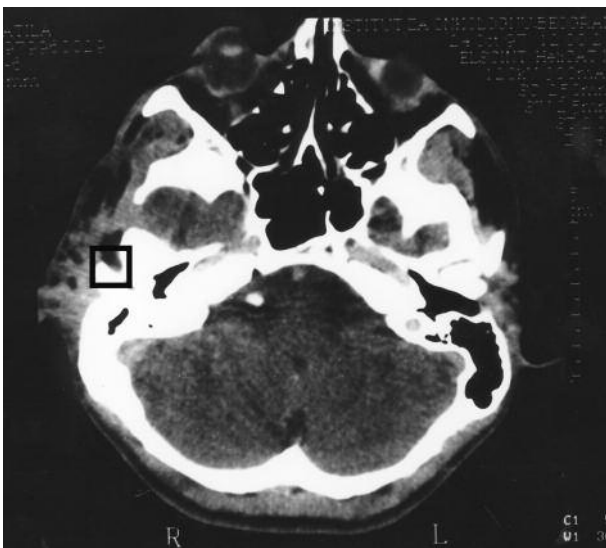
CT scan shows atretic ear (black window) of the right side
